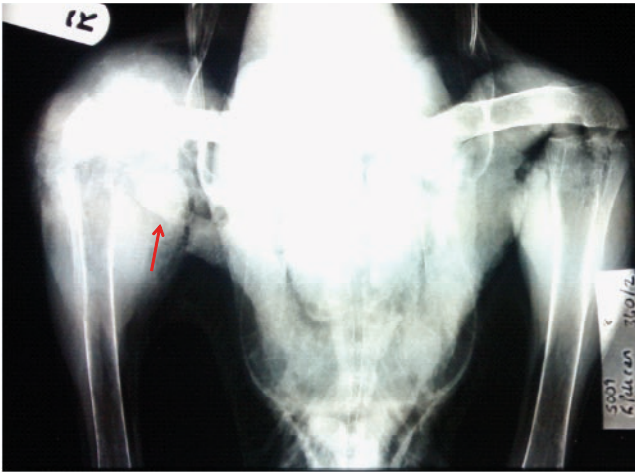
Radiograph of the pelvic area and both stifles. Note the increased radiodensity around the right stifle (marked R) compared to the left, with disruption of the osseous detail of the distal femur and proximal tibiotarsus, with additional radiodense structures present in the soft tissue immediately surrounding the joint (arrow).
